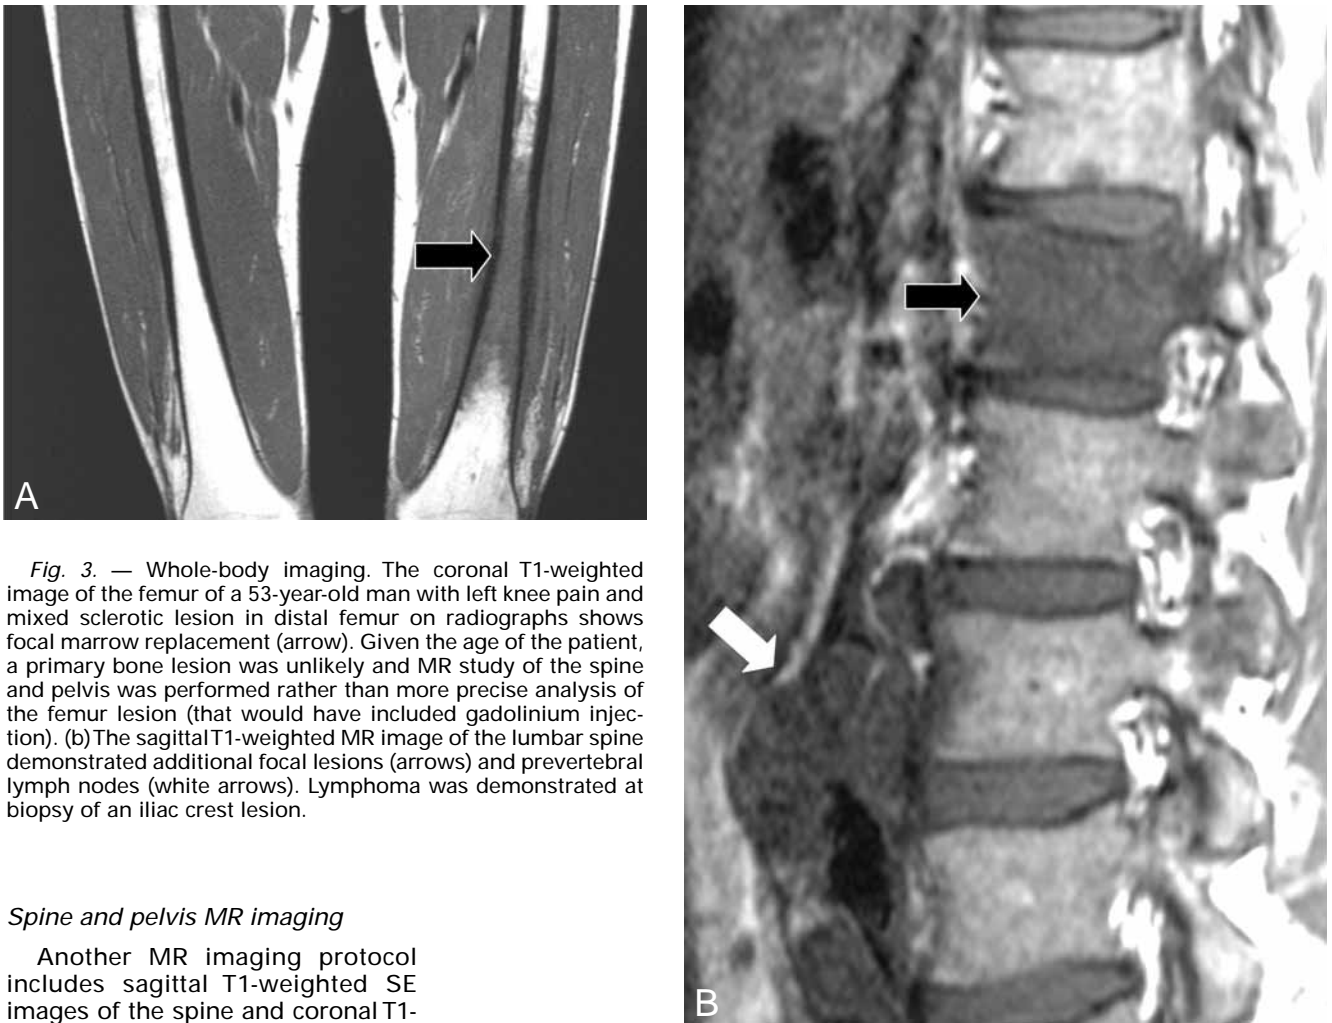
Whole-body imaging. The coronal T1-weighted image of the femur of a 53-year-old man with left knee pain and mixed sclerotic lesion in distal femur on radiographs shows focal marrow replacement (arrow). Given the age of the patient, a primary bone lesion was unlikely and MR study of the spine and pelvis was performed rather than more precise analysis of the femur lesion (that would have included gadolinium injection). (b) The sagittal T1-weighted MR image of the lumbar spine demonstrated additional focal lesions (arrows) and prevertebral lymph nodes (white arrows). Lymphoma was demonstrated at biopsy of an iliac crest lesion.
